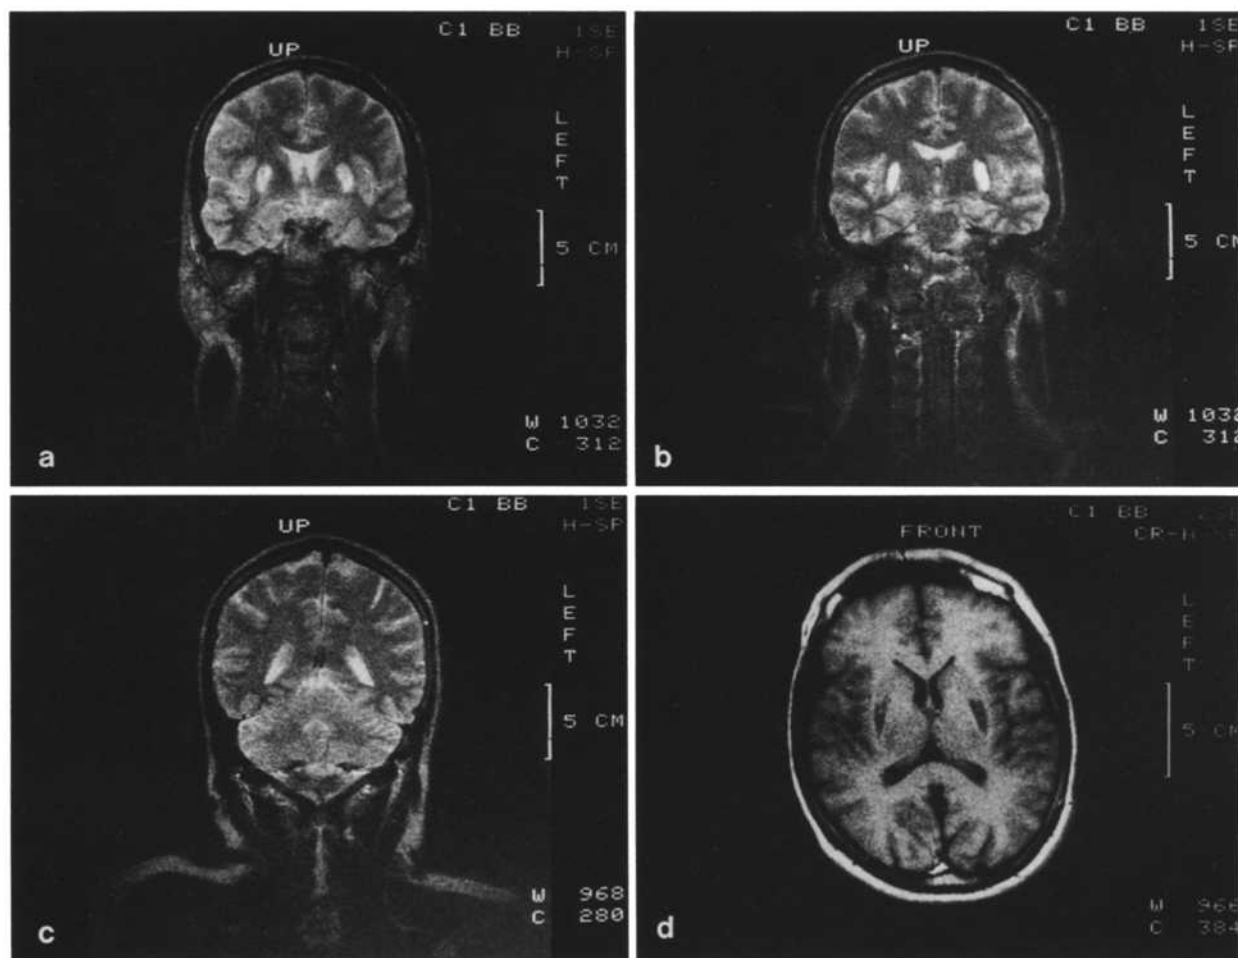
a–c Magnetic resonance imaging (MRI). Coronal sections 2 months after ingestion of poison. In T2 weighting, there is symmetrically arranged signal elevation which corresponds to the putamina. d MRI. Horizontal section. Signal reduction in T1 weighting. These results had not altered 3 months later
